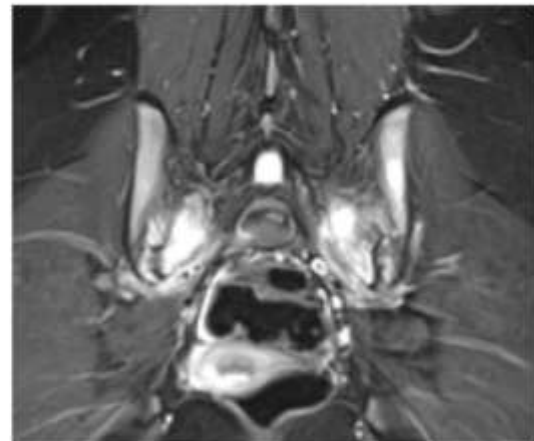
Bone marrow edema in both sacroiliac joints on whole-body MRI
